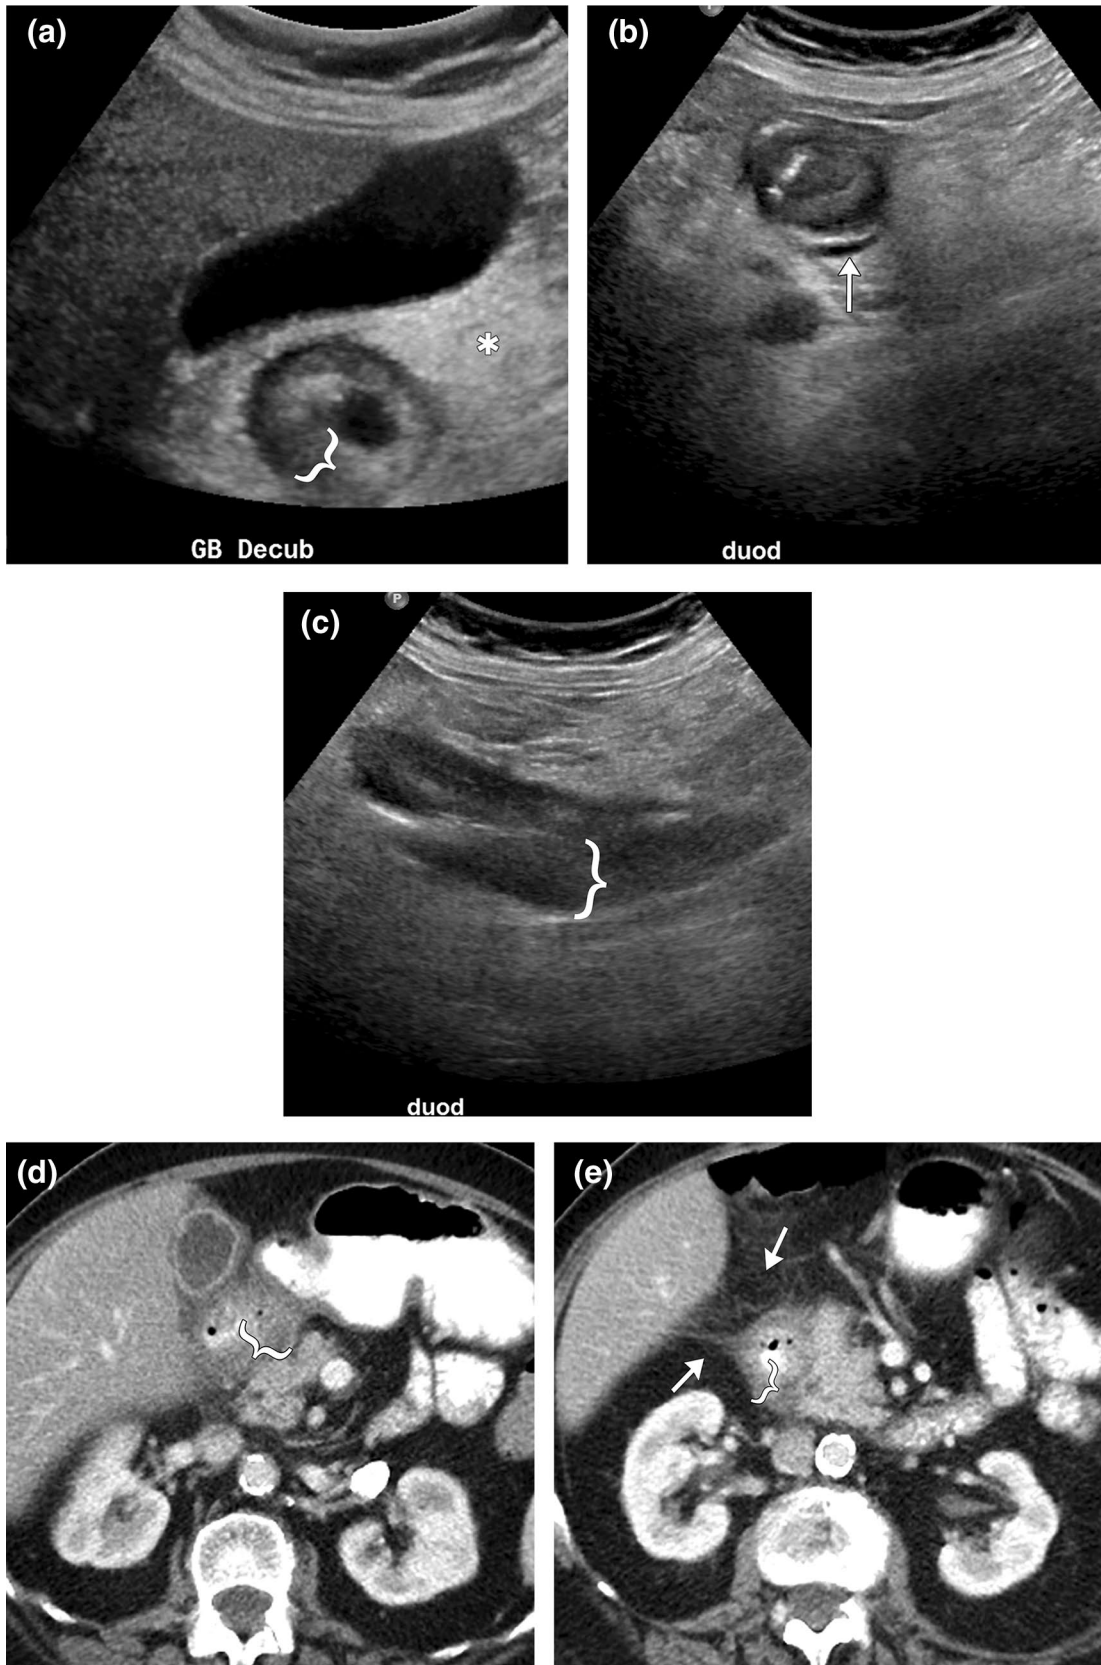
Duodenitis in an 84-year-old female with epigastric pain for 1 month. a, b Transverse gray scale images of the descending portion of the duodenum demonstrate markedly thickened duodenal wall (brackets). A small amount of free fluid is noted adjacent to posterior wall of the duodenum (arrow in b). c Gray scale image obtained in longitudinal plane demonstrates marked thickening of the descending and part of horizontal portions of the duodenum. Note echogenic fat around the duodenum compatible with inflammation (asterisk). d, e Contrast-enhanced CT images in the axial plane show marked thickening of the first and second portions of the duodenal wall (brackets) and inflammatory changes in the peri-duodenal fat (arrows). Note that the pancreas is not involved (P)
